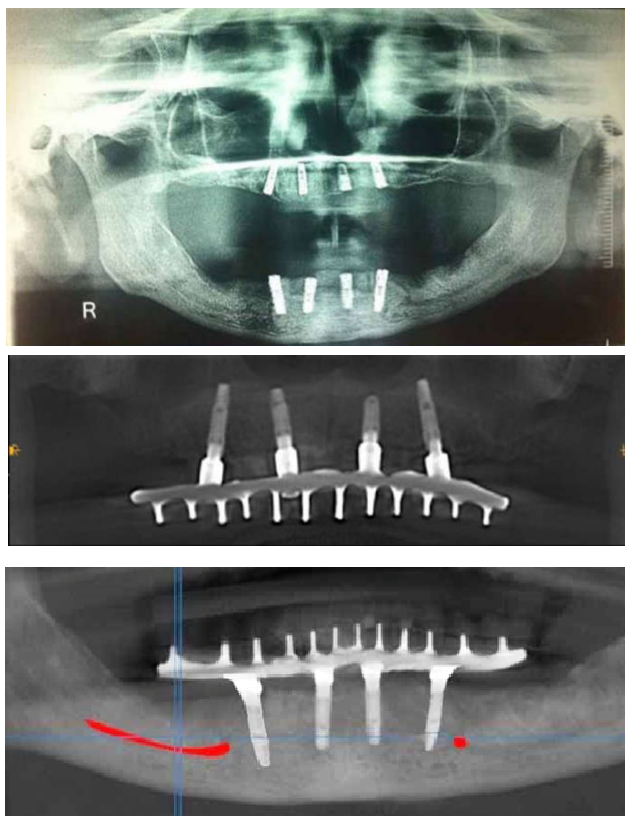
4 years comparative radiographic evaluation
